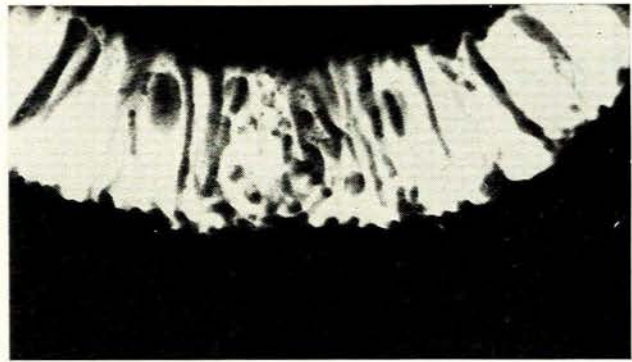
Radiograph of intact, living, barium-filled baboon jejunum. Filled, inactive state, showing circular mucosal folds (oval radiolucent areas are collections of intestinal gas).
